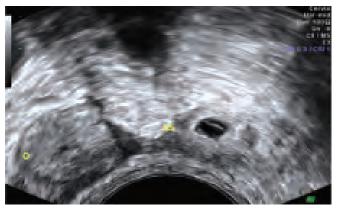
Transvaginal ultrasound of ectopic pregnancy. Gestational sac (GS) is visualized adjacent to the ovary (O)
